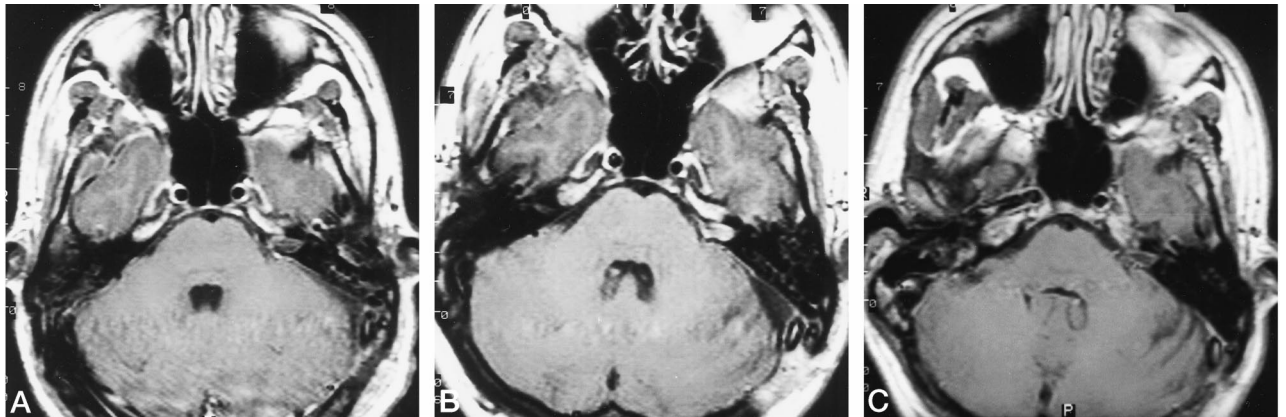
Contrast-enhanced axial T1-weighted MR images after resection of a small acoustic neuroma show changes in surgically induced enhancing patterns at different imaging times.
